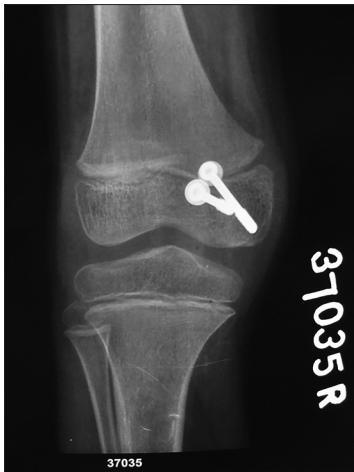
Post-op Xray AP
